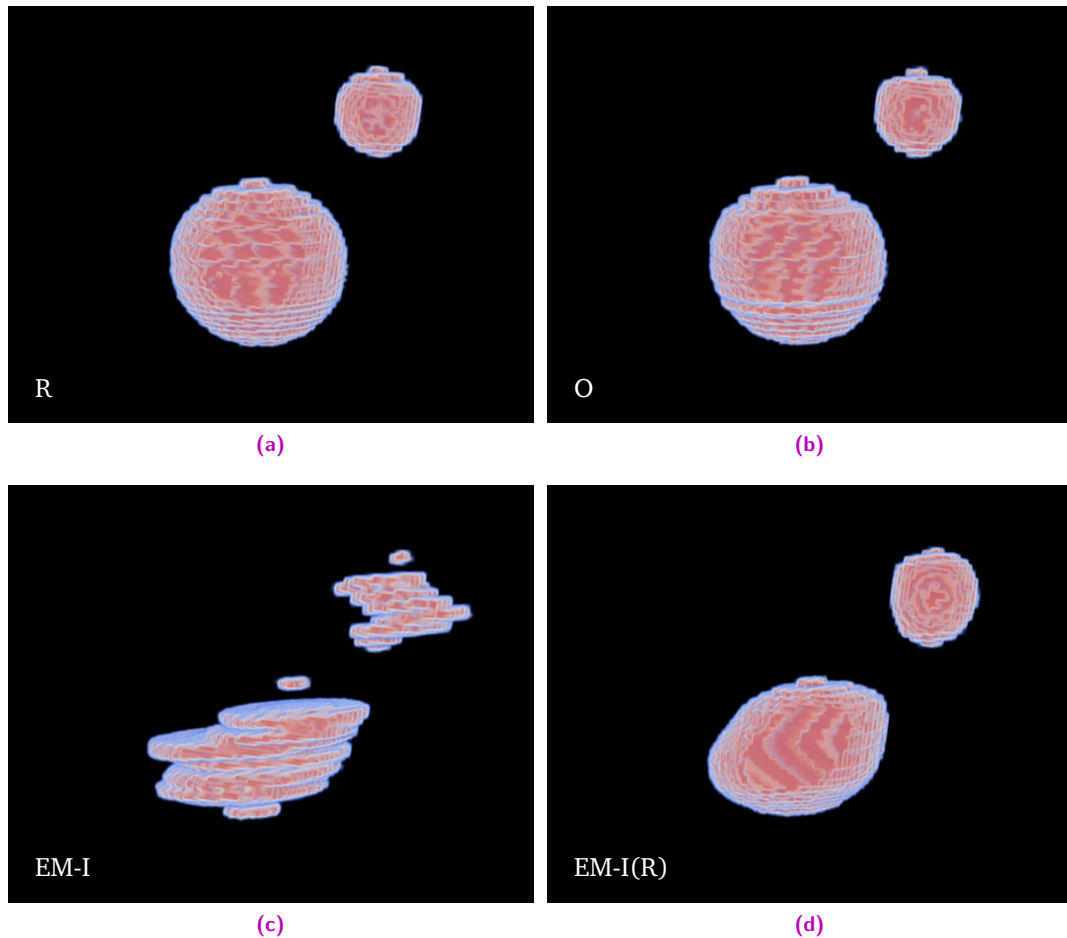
Results of ultrasound compounding reconstruction of synthetic data. The data is generated by reslicing the synthetic volume according to mechanical tracking data. Unsurprisingly, the volume reconstruction obtained according to the same tracking information lead to the best perceived quality (a). Optical tracking agreed almost perfectly with mechanical tracking, and the result of the reconstruction confirms this observation (b). The data from the integrated EM sensor turned into the worst results (c). However, our regularization method is still able to lead to an intelligible result even in the worst case among all our acquisitions, which is the one reported in this figure.
